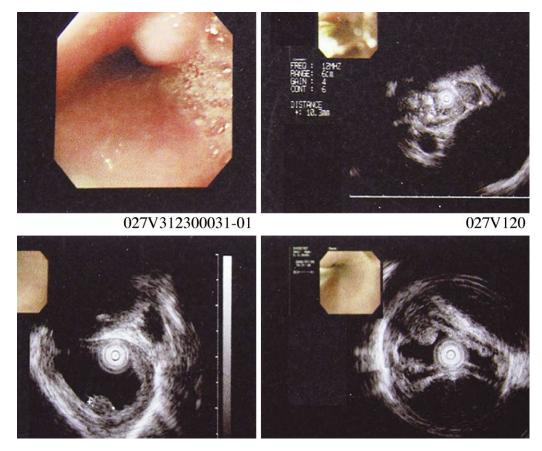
Endoscopic ultrasound study: a 6.3 mm well-defined margin mixed echoic tumor from the esophageal mucosa layer with intact underlying submucosa and muscularis propia layers.
